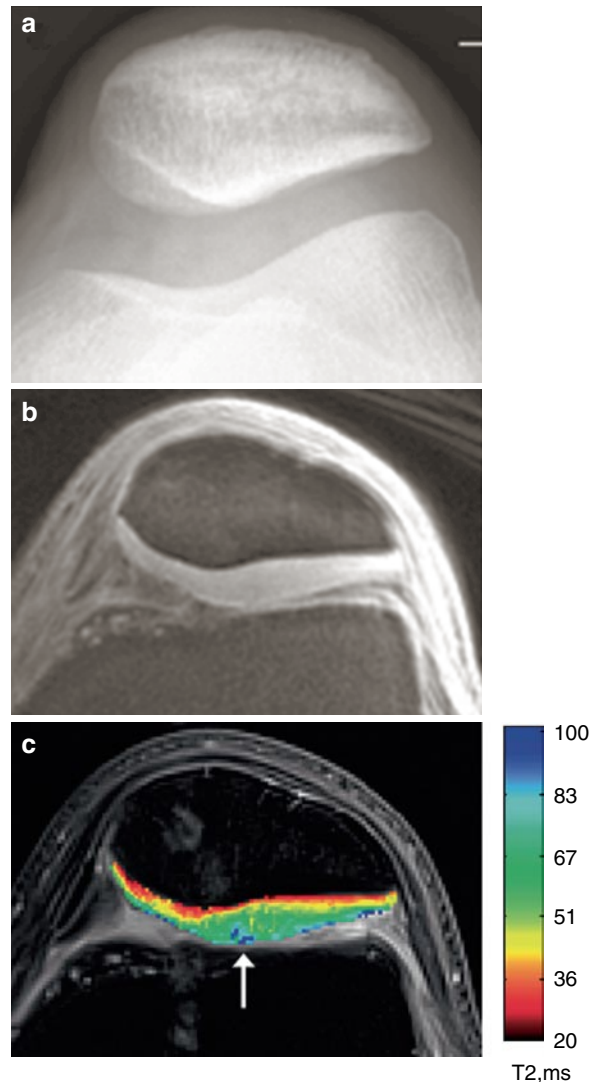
Quantitative MRI T2 Map. (a) Radiographs and (b) structural MRI do not show signs of cartilage damage. (c) On the MRI T2 map, full-thickness focal lesion of high T2 values is noted to the central pole of the patella (white arrow). This finding shows chondromalacia patella. Although the cartilage appears quite thick, the lack of distinct laminae on T2 map further shows that the microstructure and the biochemical composition of the tissue is abnormal
